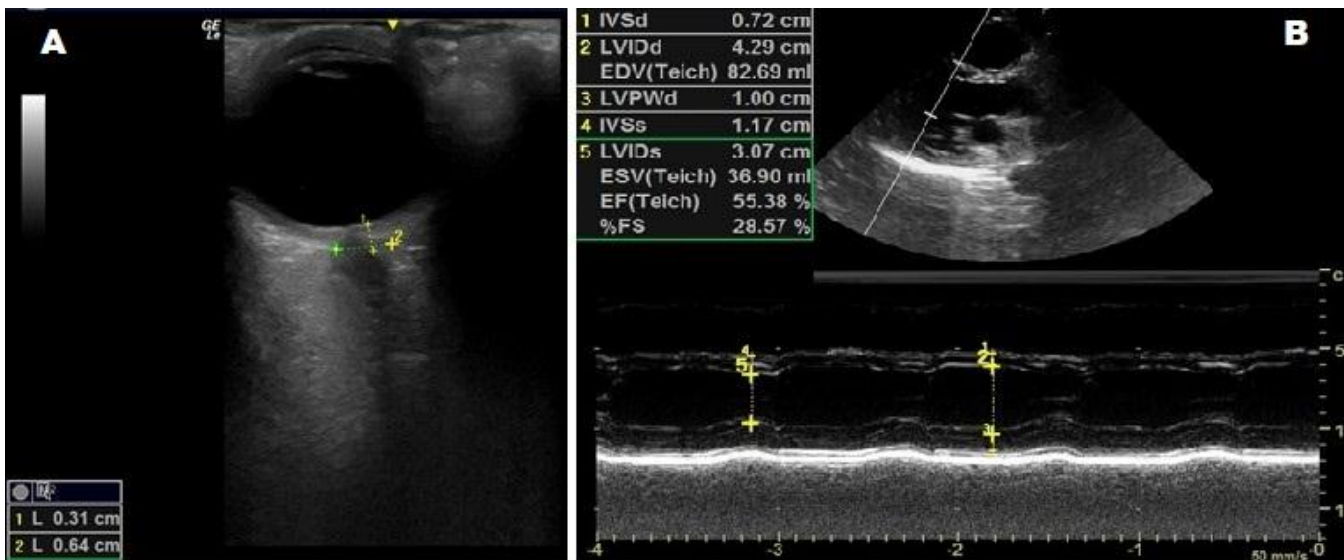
(A) A transverse orbital ultrasound image shows the optic nerve sheath at 6.4 mm, 3 mm behind the globe, (B) An echocardiography image reveals preserved systolic function (EF 55%), demonstrating ONSD utility in detecting congestion in HFpEF, where EF alone may not capture disease severity.
